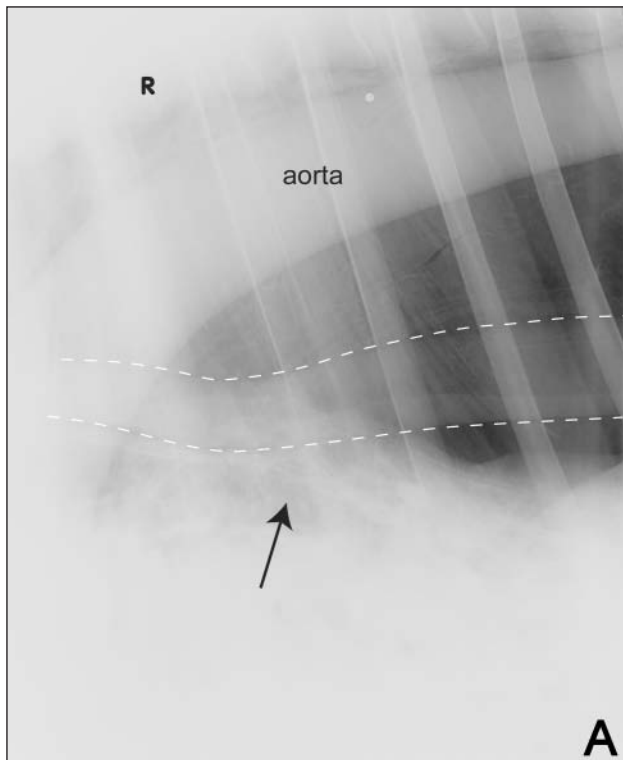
Same radiographic images as in Figure 1. The esophagus is clearly demarcated (outlined by dashed lines) dorsal to the tracheal bifurcation (arrow). Notice the radiopacity of the caudal lung lobe and its retraction from the dorsal aspect of the thorax. The margins of the aorta are sharper than normal. No normal (ie, bronchi and lobar vessels) pulmonary structures are seen.
